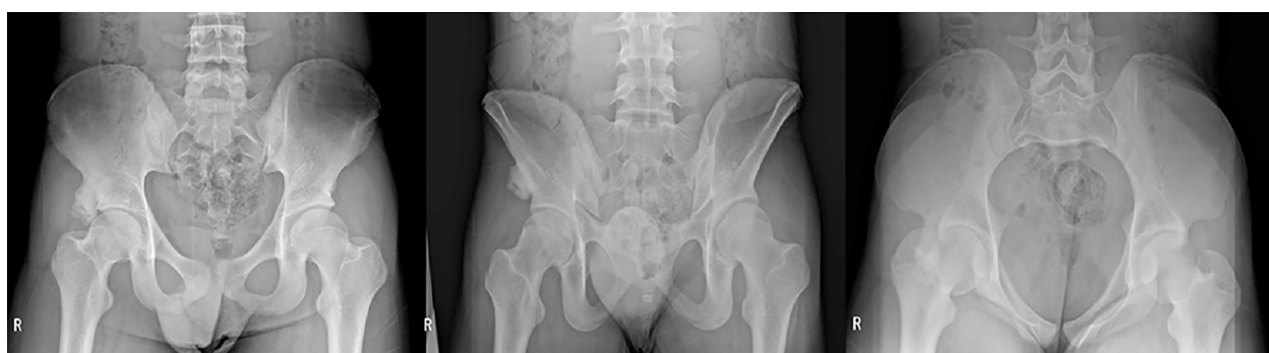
X-ray showing a round pedunculated bony protrusion on the superolateral aspect of the right anterior inferior iliac spine.
